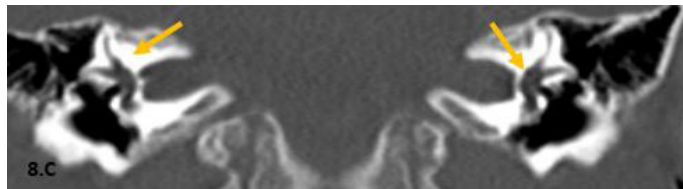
C: coronal, bone window CT view revealed normal bilateral vestibules and SCCs (yellow arrows).
